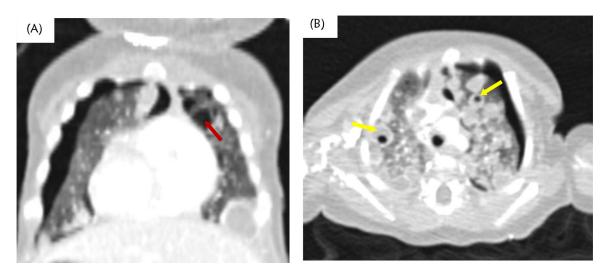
(A) Chest Ct, coronal, lung window showing right side pneumothorax and left upper lobe apical segment pulmonary cysts (Brow narrow). (B) Chest CT, Axial Lung window showing bilateral cavitating nodules (Yellow arrows).
